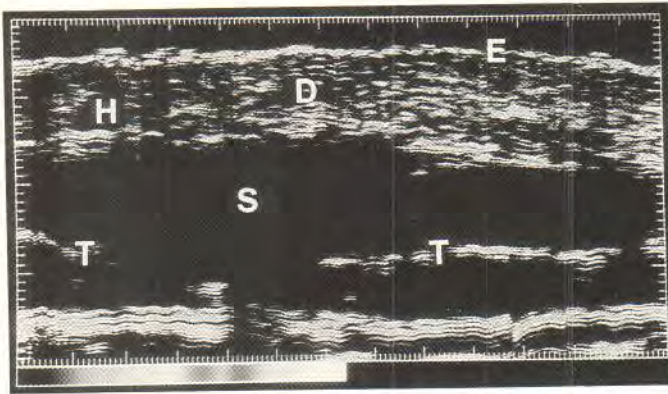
B-scan of normal skin at high pre-amplification. The distance between the smaller scaling-marks at the border of the ultrasound images is 0.1 mm, between the larger ones, 1 mm. E = skin entry echo, D = dermis, S = subcutis, H = hair follicle, T = connective tissue trabeculae.
